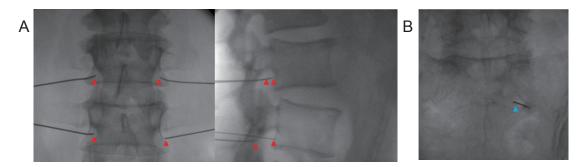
X-ray images of pulsed radiofrequency procedure.
